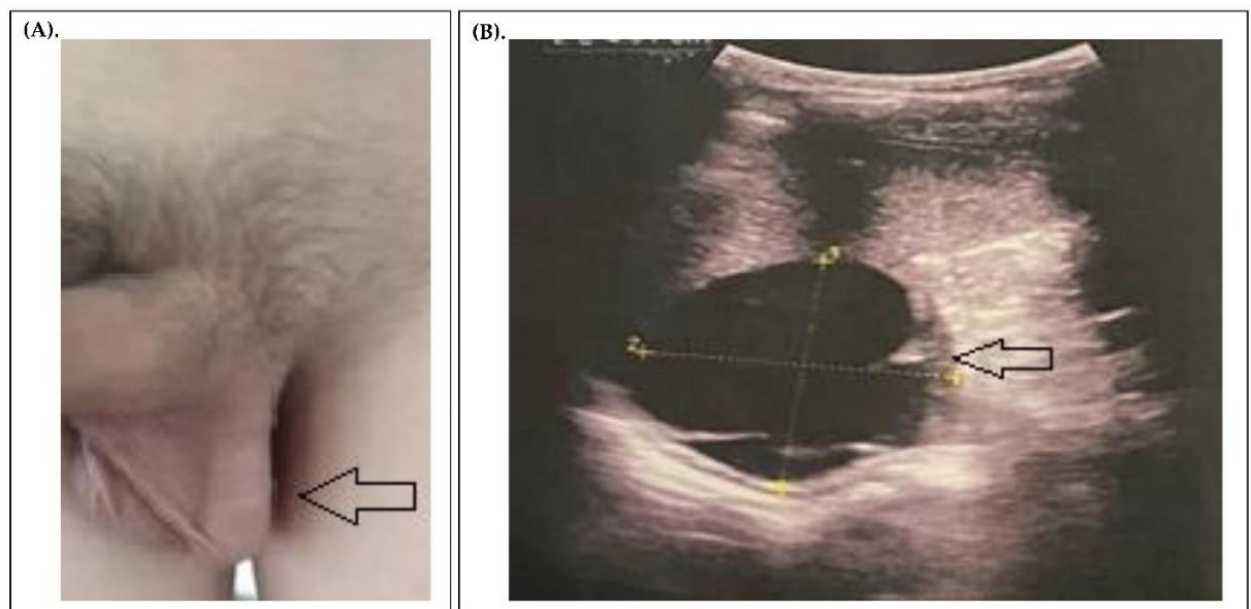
Clinical presentation and ultrasound findings. (A) Patient P, 15 years old, with varicocele of the left testicle. (B) Patient P, 15 years old, ultrasound showing a cyst of the lower pole of the spleen.
